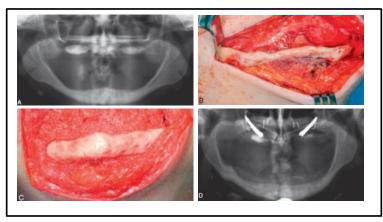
Augmentation of atrophic edentulous mandible. (A) Preoperative radiograph. (B) Surgical exposure (C) Bone graft in place. (D) Six-month postoperative radiograph. Note that the bone graft area is not as dense as underlying bone. When implants are placed and stress is applied, the density will increase (Hupp *et al.*, 2019).
